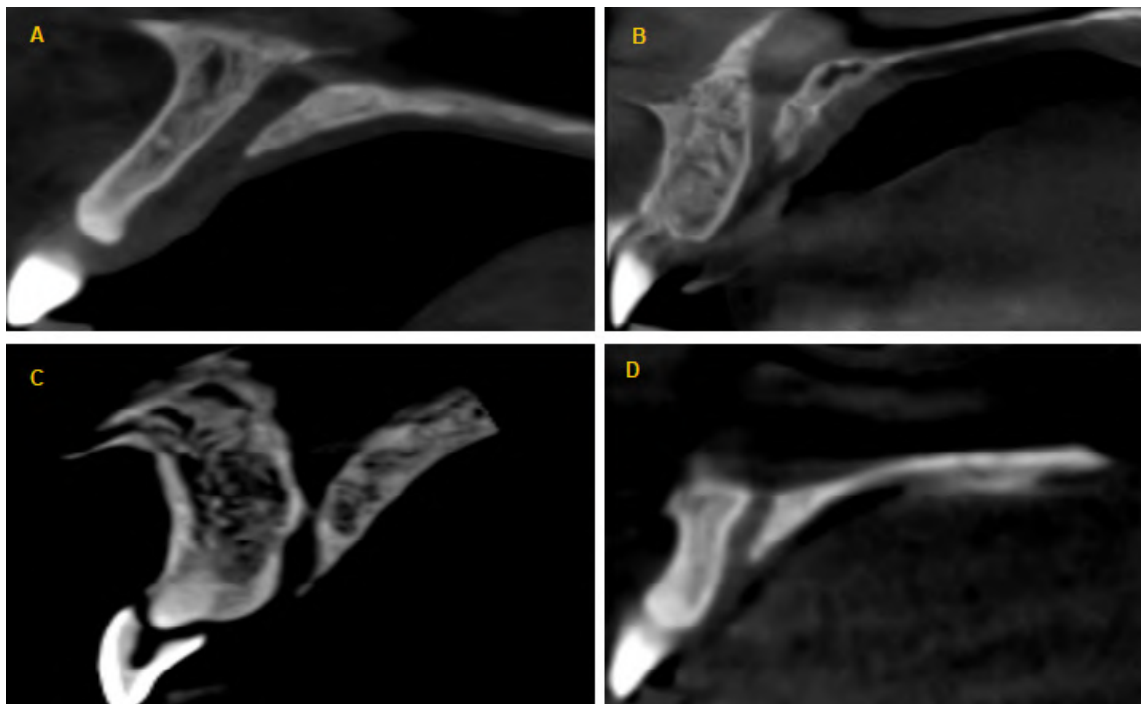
CBCT Images of NPC configuration in Sagittal section. (A = Cylindrical canal, B = Funnel canal, C = Hour glass canal, D = Spindle canal).
